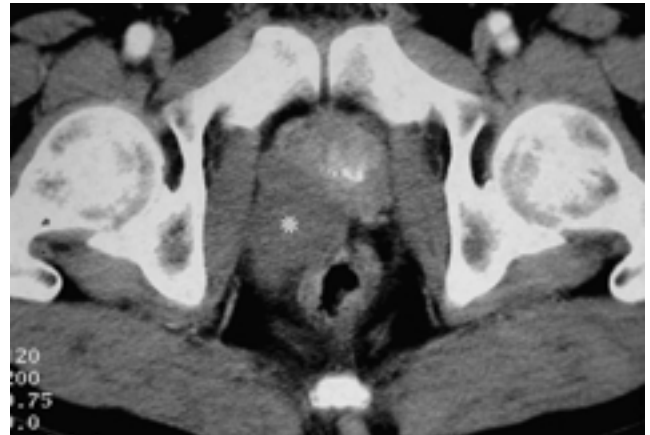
CT scan obtained 2 months after percutaneous embolization shows the disappearance of the dilated veins and the formation of thrombus in the venous aneurysm(asterisk).
